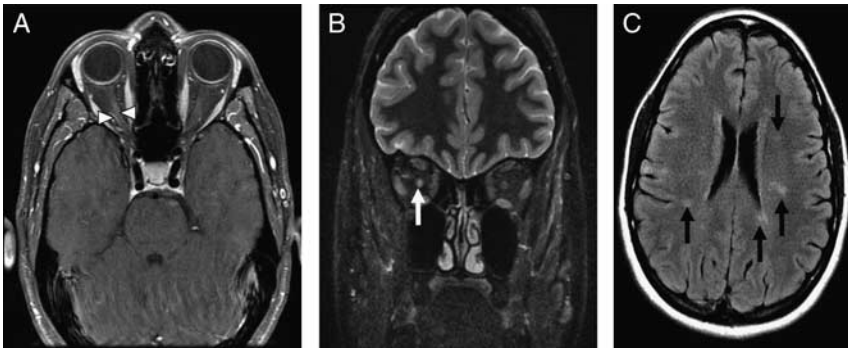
37-year-old woman developed painful right eye movement and was found to have an afferent pupillary defect and optic nerve edema on examination. Axial T1-weighted postcontrast fat-saturated MRI demonstrates asymmetric enhancement and enlargement of the right optic nerve (A, white arrow heads). Coronal T2-weighted MRI demonstrates abnormally increased T2 hyperintensity within the right optic nerve (B, white arrow). Axial FLAIR MRI demonstrates periventricular T2 hyperintense lesions oriented perpendicular to the lateral ventricles consistent with multiple sclerosis (C, black arrows). FLAIR indicates fluid attenuation inversion recovery; MRI, magnetic resonance imaging.
